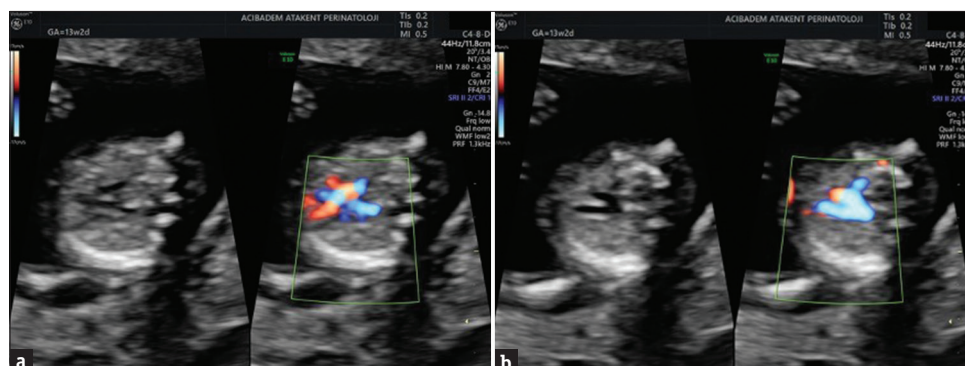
(a) Outflow tracts, (b) Three-vessel trachea views were assessed by HD-flow Doppler exam
